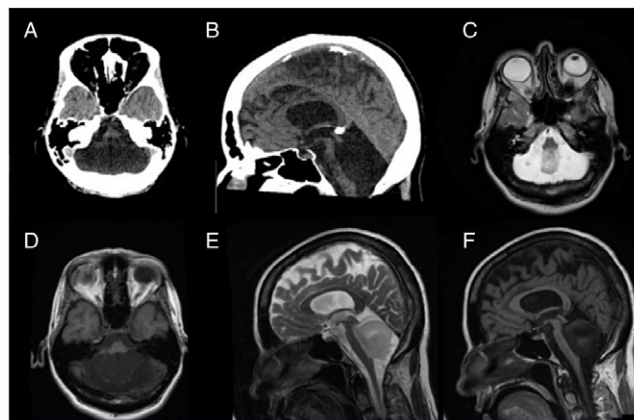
(a) and (b) CT showing CSF density in posterior fossa, thinning of the brainstem. (c–f) MRI confirming complete cerebellar agenesis, hypoplastic pons with bowtie appearance due to lack of input from cerebellar peduncles.
